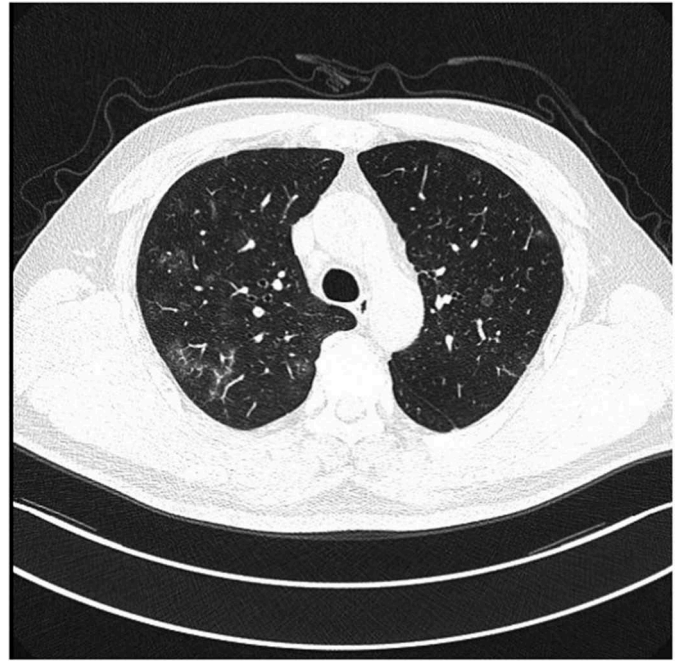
Chest CT of case 1, on 28 January 2020.
